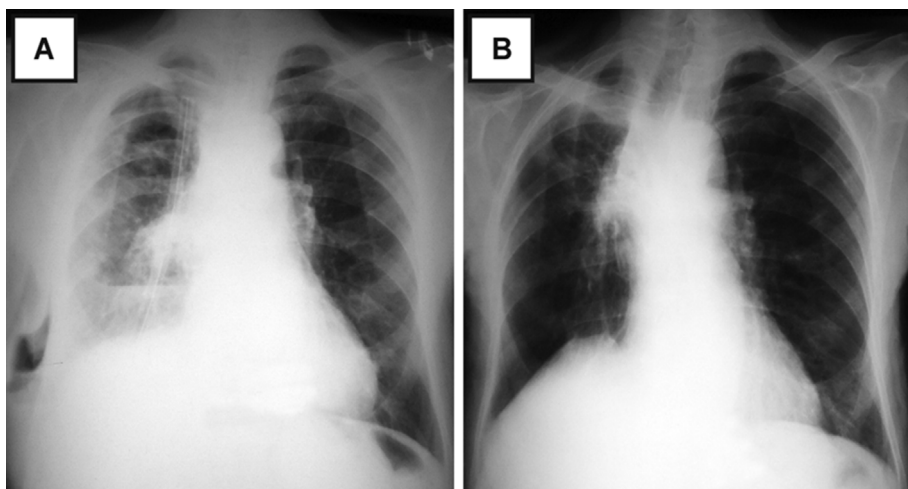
A chest X-ray of 80 year-old male, showing a mass tumor in right lung. After bronchoscopy, a diagnosis of squamous cell lung carcinoma was achieved. An axillary lymph node was detected and biopsy was performed. Pathology of the biopsy showed granulomatous inflammation with caseous necrosis. (A) Chest X ray during diagnosis of TB and (B) following for TB treatment.
